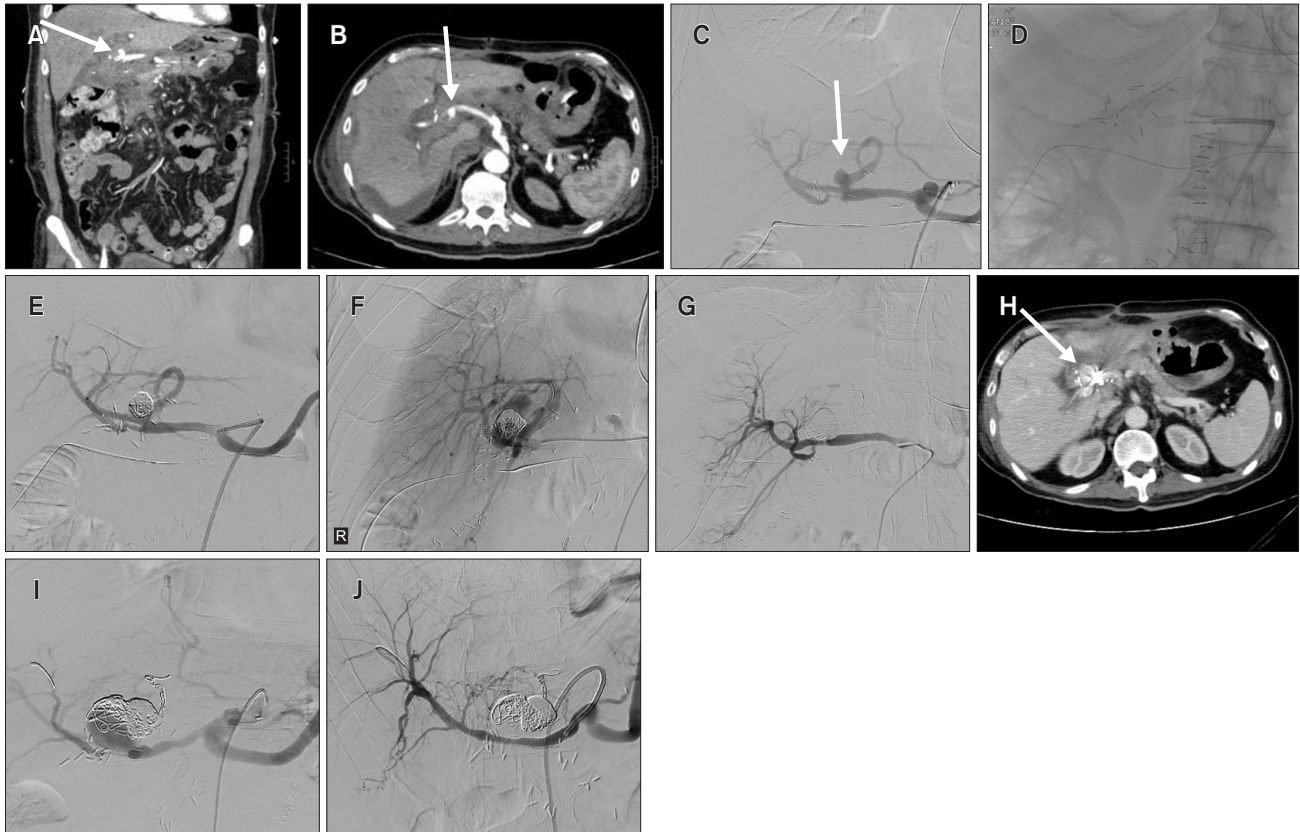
Images for Case 4. (A) The coronal view on computed tomography (CT) 2 weeks after Whipple operation showed a ≤ 0.7 cm saccular pseudoaneurysm over the origin of the left hepatic artery (arrow). (B) The axial view of the CT also showed a ≤ 0.7 cm saccular pseudoaneurysm (arrow). (C) The celiac angiography confirmed the presence of a saccular aneurysm originating from the origin of the left hepatic artery (arrow). (D) Stent deployment was performed to assist the coiling of the aneurysm. (E) The celiac angiography after the stent-assisted coiling showed loose packing of the coil, which allowed for partial embolization. (F) The common hepatic angiography showed enlargement of the known pseudoaneurysm despite coiling one day prior. (G) The common hepatic angiography after coiling of the left hepatic artery and pseudoaneurysm sac showed complete obliteration of the artery and the pseudoaneurysm. (H) CT showed regrowth of the pseudoaneurysm despite previous coiling (arrow). (I) A common hepatic angiography confirmed the regrowth of the pseudoaneurysm with the involvement of the right hepatic artery. (J) The common hepatic angiography after the deployment of a flow diverter and covered stents to the right hepatic artery showed elimination of the pseudoaneurysm along with preserved right hepatic artery blood flow.
